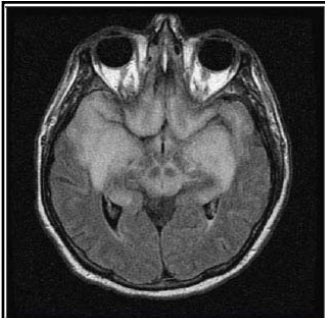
Axial Fluid-Attenuated Inversion Recovery MRI Scan Showing Profound Signal Abnormalities within the Bilateral Frontal and Temporal Lobes, Hippocampi, Basal Ganglia, and Medulla in Patient 2.
